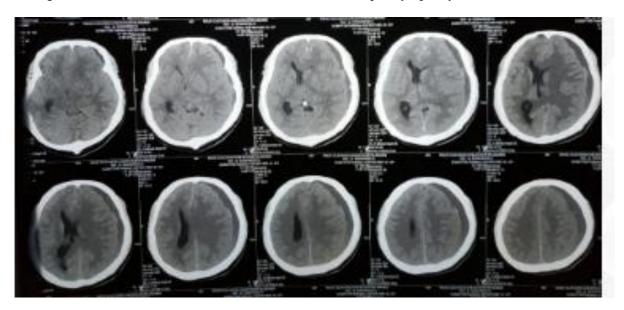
Head CT Scan Non Contrast of Anemia Aplastic Patient with Subdural Hematoma. There was a Midline Shift and Hipodense Crescent Appearance at Left Frontoparietal with Thickness Maximum was 2
